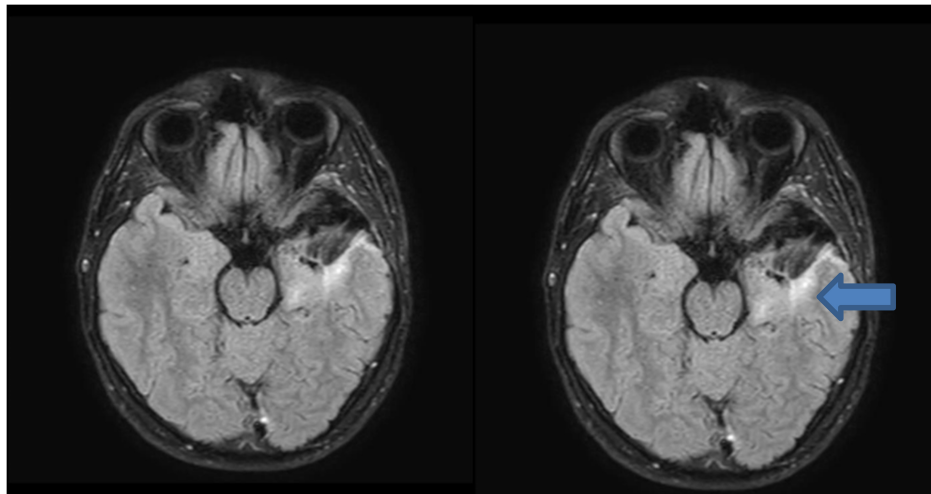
Postoperative T2 FLAIR signal (presence of postoperative residue).
